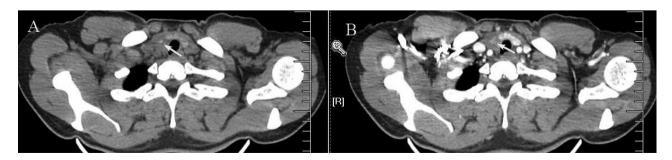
(A) Nonenhanced CT shows a soft tissue density mass without calcification. (B) On a contrast-enhanced CT, the corresponding lesion appears slightly enhanced.
